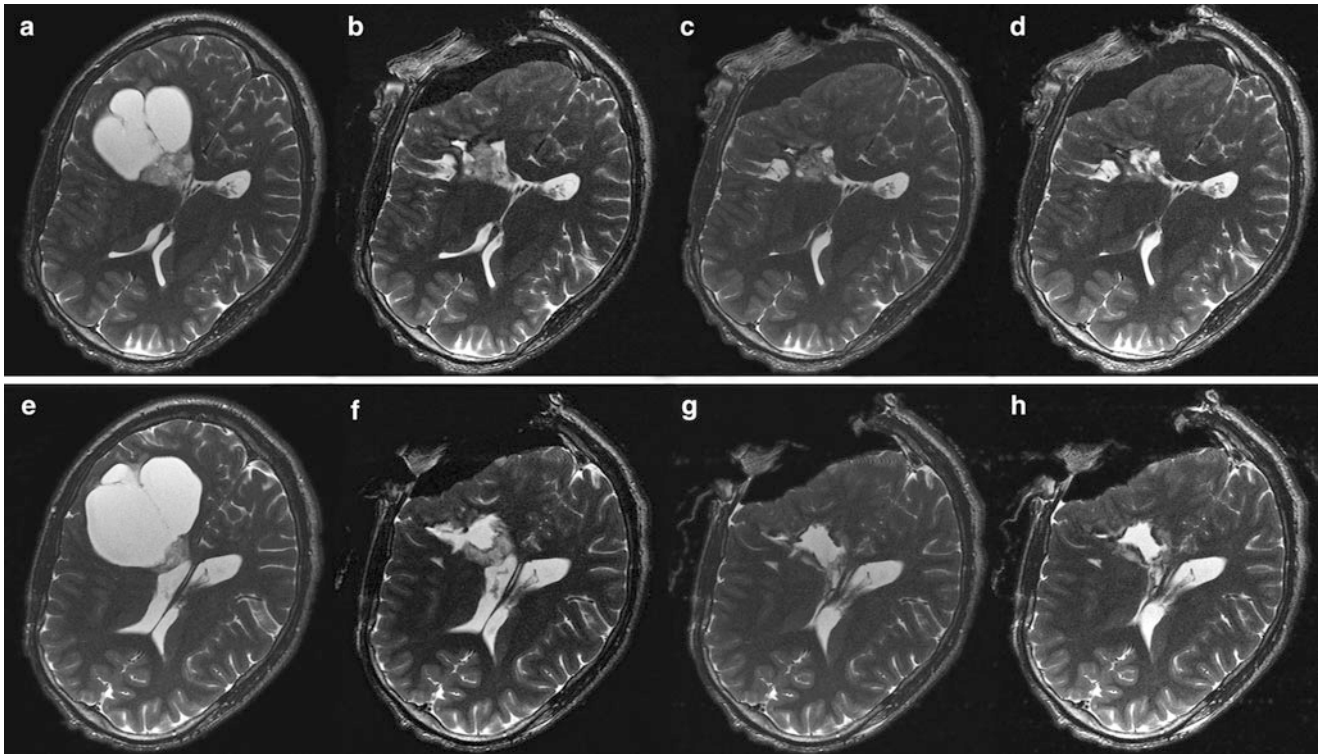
Same patient as in Figs. 1 and 2 depicting the course of resection in two slice positions that were identical in all 4 imaging sessions (pre: a/f, iop1: b/f, iop2: c/g, iop3 d/h, all images axial T2-weighted, slice thickness 3 mm, difference between slice positions row a–d to row e–h: 9 mm), note the different portions of brain shift first after opening the large tumor cysts (difference a/e to b/f) and additionally after first updating collapsing of the left frontal ventricular horn (f to g)
